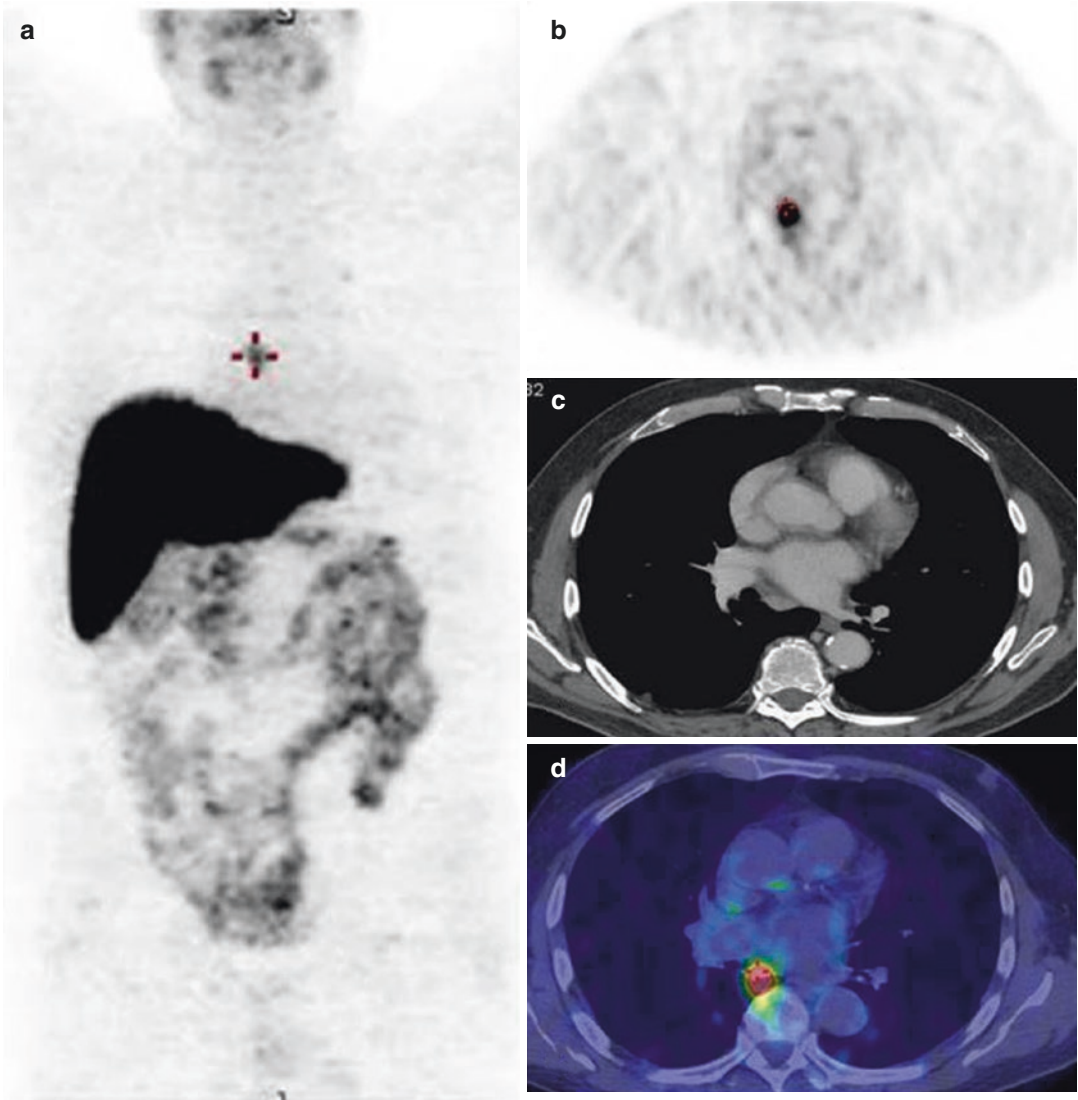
In a patient examined for biochemical relapse (PSA 3.2 ng/ml) three years after radical prostatectomy, ^{64}Cu -PSMA PET 3D maximum intensity projection (a)
